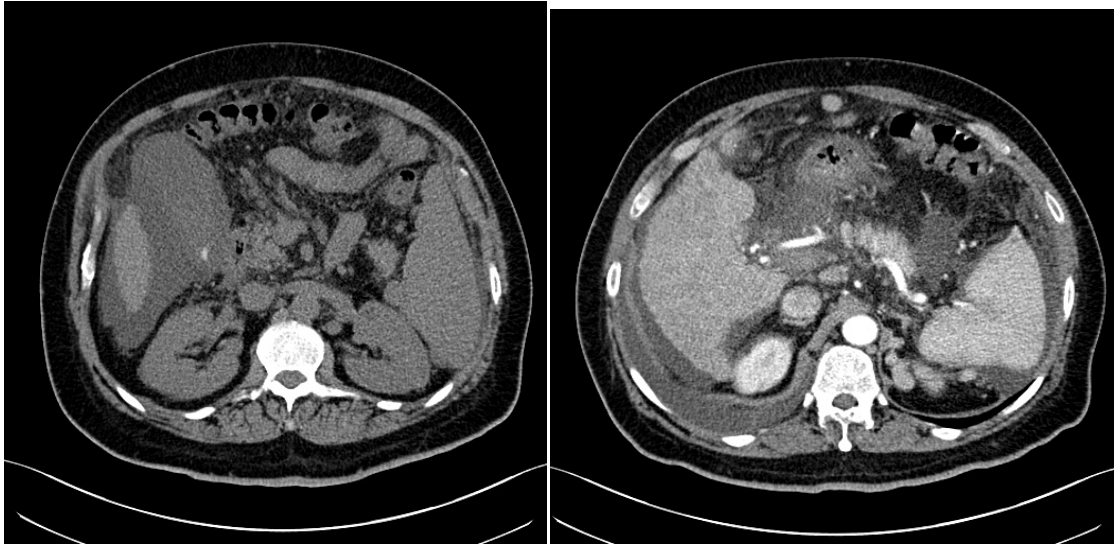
68 yrs Female axial CT Cirrhotic liver ,the left image same pt in arterial phase
